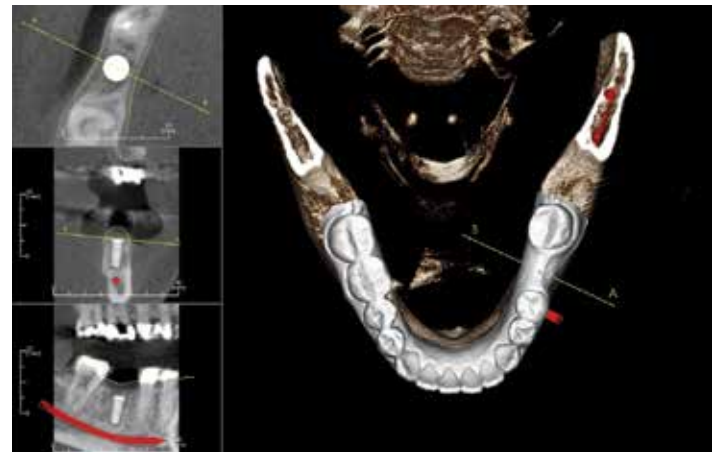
Same patient as depicted in Figure 6, however, an optical image of the dentition is overlaid on the CBCT scan, giving the ability for a clear and precise interpretation of the dental structures surrounding the proposed implant site
